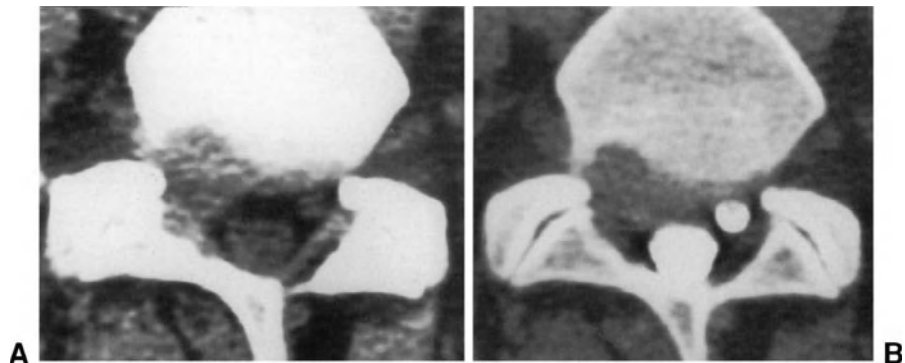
Myelo-CT scans in a patient with an osteochondral avulsion of the posterosuperior border of the L5 vertebral body. The axial scans at L4-L5 level show a herniated disc and a defect in the posterior portion of the vertebral body (A) and (B) and a bony fragment impinging on the thecal sac (B). The osteochondral avulsion is clearly visible on the sagittal reconstruction (C).
